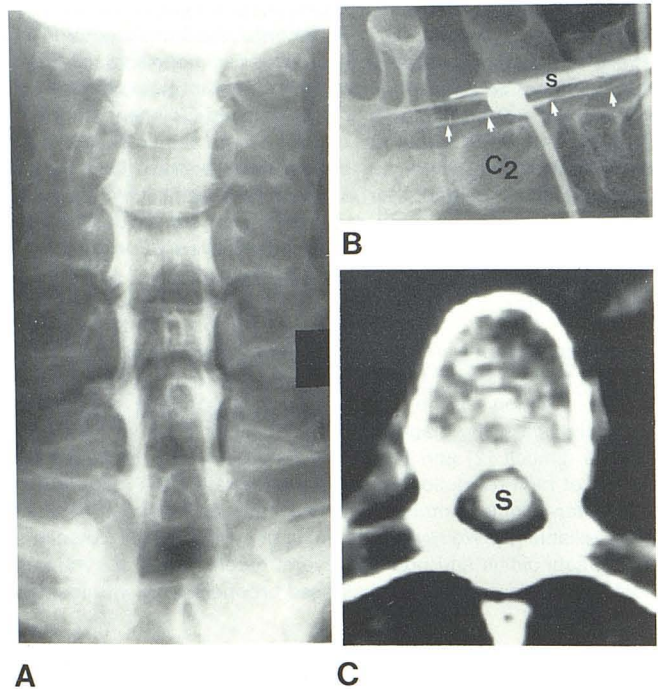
Case 3. Direct syrinx puncture in 66-year-old man with severe arachnoiditis and progressive arm weakness. A, Cervical myelogram. Cervical cord is slightly enlarged. B, Lateral cervical spine film after direct C1–C2 puncture of syrinx. Two contrast layers are within syrinx (s) and subarachnoid space (arrows). C, Immediate CT scan. Syrinx (S) extends from C2 to conus. Caudal extent allowed thoracic rather than cervical shunting of syrinx.
